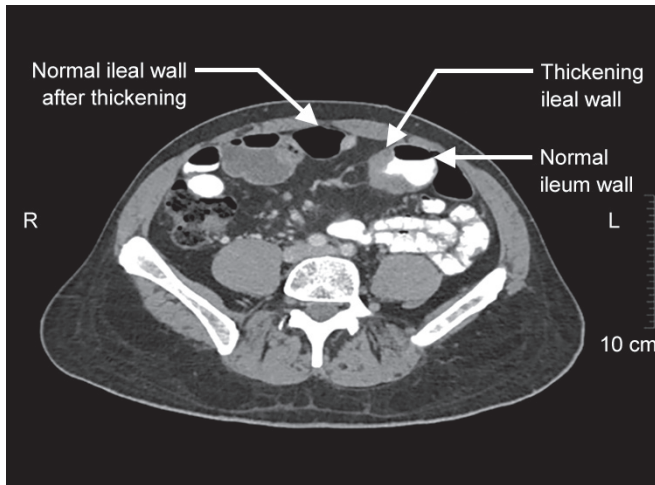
Computed tomography showing thickened ileal wall
